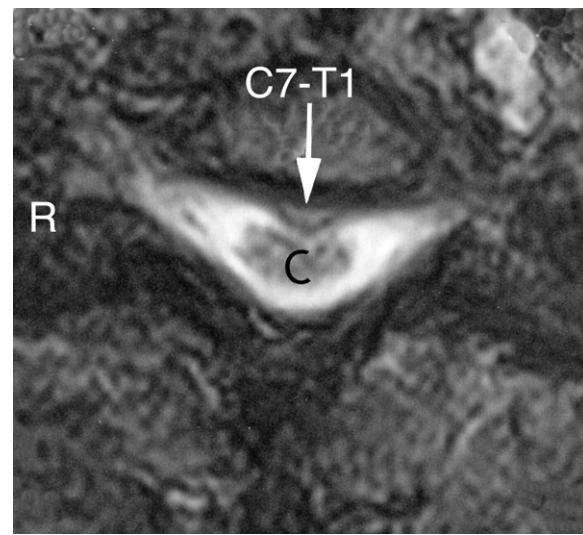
Cervical spine MRI T2-weighted axial image at C7-T1. Note the posterior and centrally located C7-T1 intervertebral disc protrusion (arrow) pressing upon the anterior part of the spinal cord (C).
